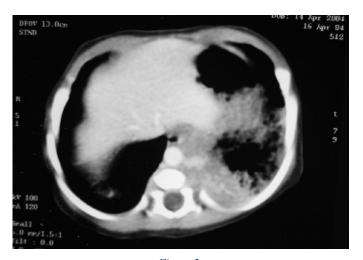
CT Scan Chest Lung Parenchyma Producing a Solid Density in the Posteromedial Segment of Left Lower Lung
